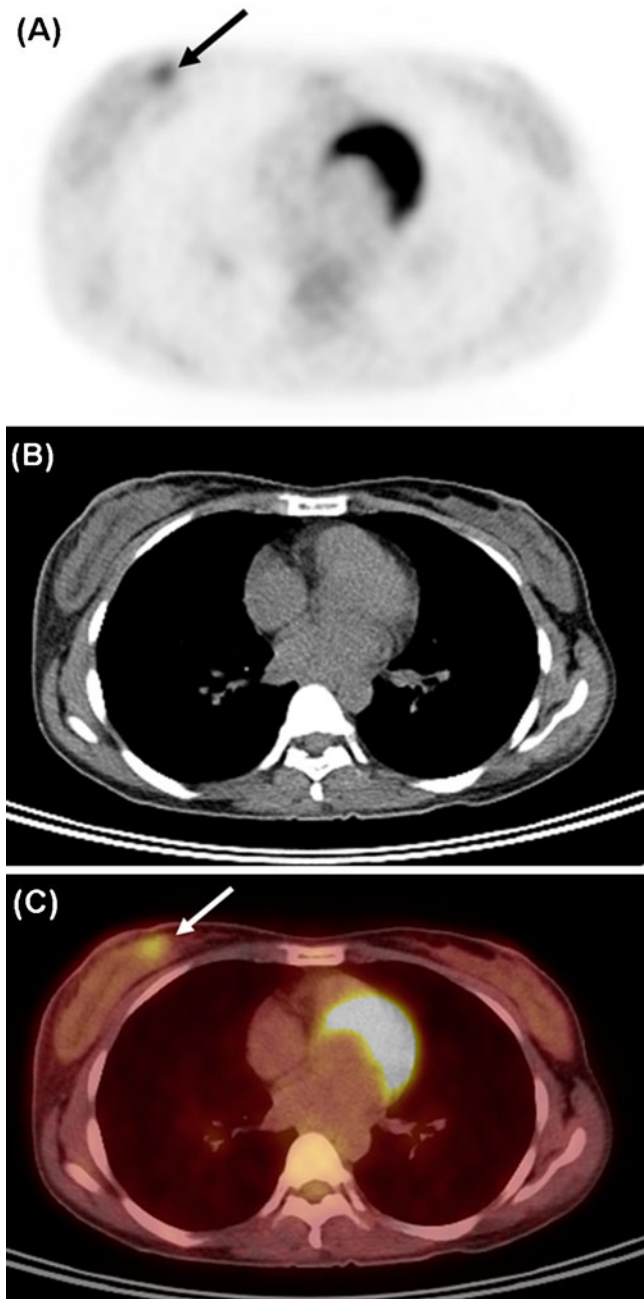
Transaxial ^{18}F -FDG PET (a), CT (b) and fused ^{18}F -FDG PET/CT (c) images of the right breast lesion. A moderate focal ^{18}F -FDG uptake with maximum SUV of 2.4 is seen in the right breast (arrow in a and c) which was diagnosed with invasive ductal breast carcinoma
